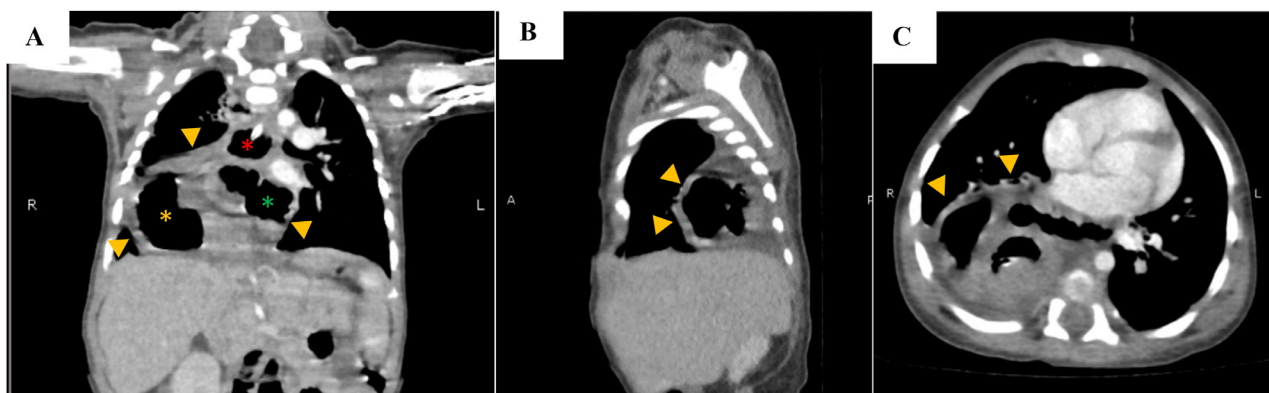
Mediastinal window chest CT shows a Type IV hiatal hernia. Coronal (A), sagittal (B), and axial (C) reconstructions all shows the hernial sac (yellow arrowhead). Coronal (A) and axial (C) views also show the short oesophagus (red star), stomach (yellow star), and duodenum (green star).
